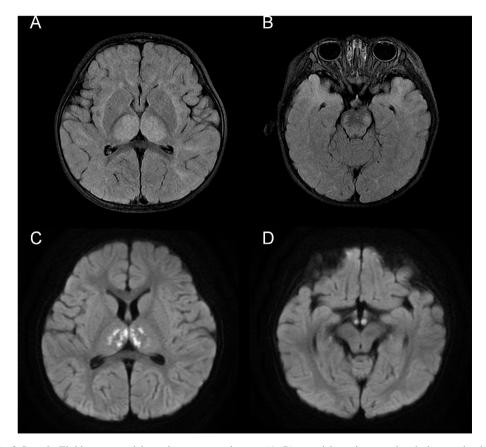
Brain MRI of Case 2. Fluid attenuated inversion recovery images (A, B) reveal hyperintense signal changes in the bilateral thalamus, external/extreme capsule, brainstem tegmentum, and mammillary bodies as well as multifocal foci in cerebral and cerebellar white matter. Diffusion-weighted images (C, D) show diffusion restrictions in the bilateral thalamus and mammillary bodies.
